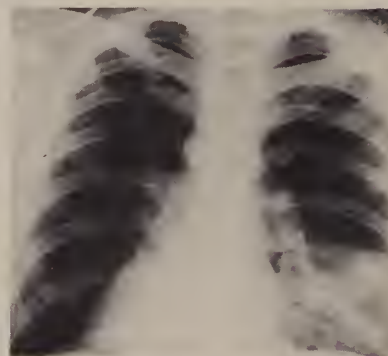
Case R. W. Radiograph of chest on admission.
